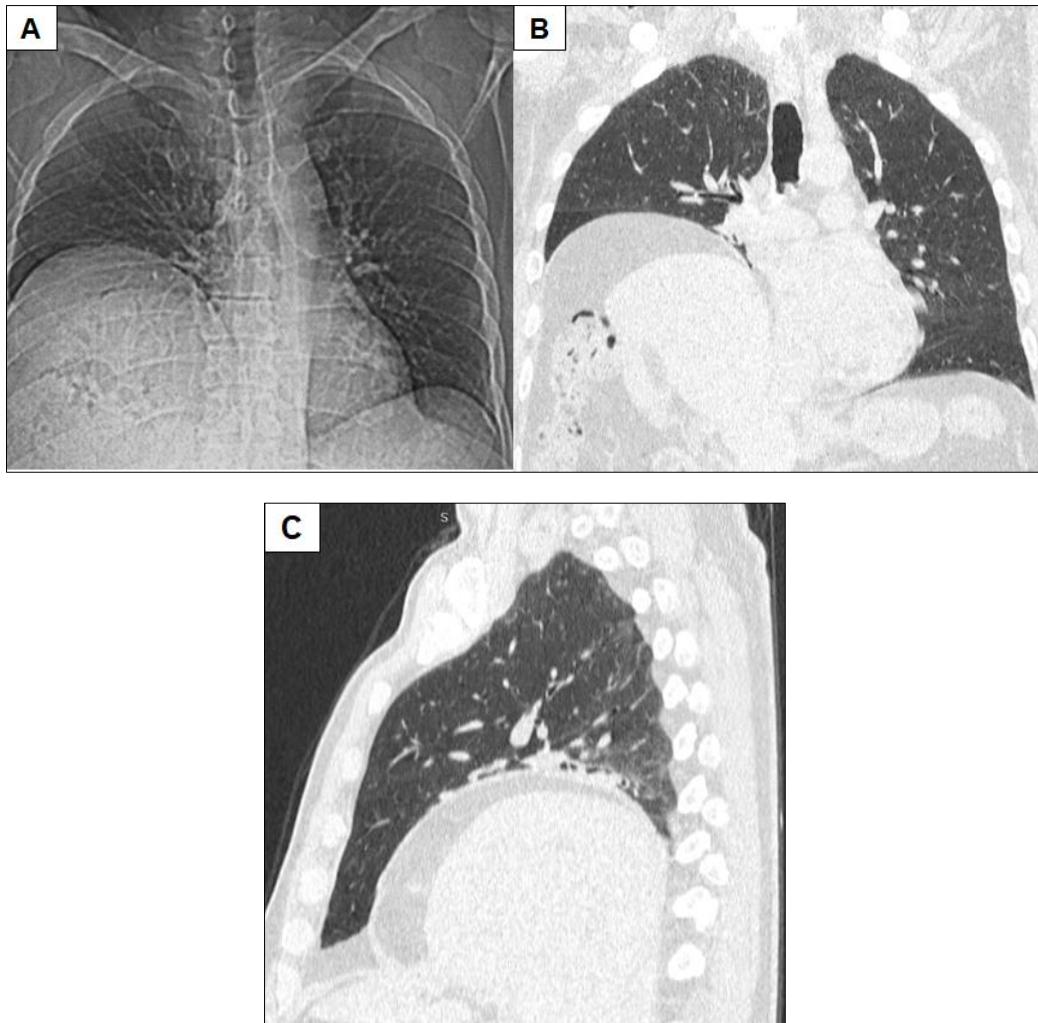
Chest x-ray (A), coronal (B) and sagittal (C) thoracic CT scan images showing an elevation of the right diaphragmatic dome
